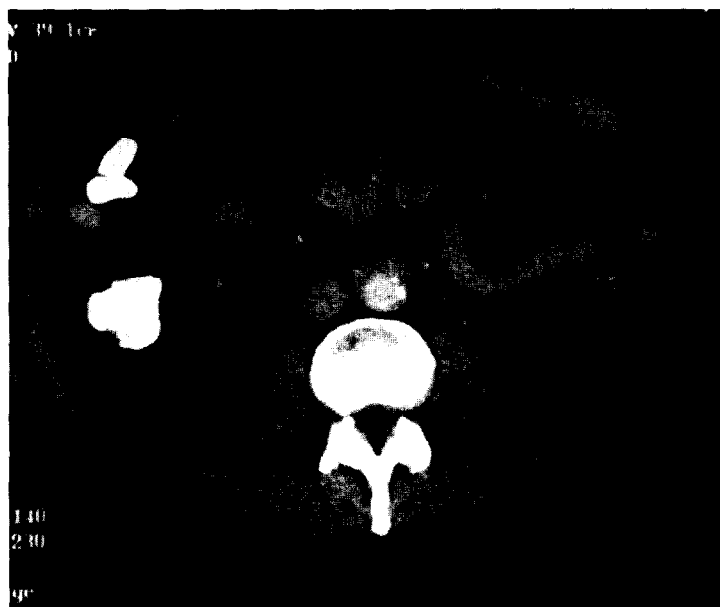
CT scan demonstrating an infiltrative mass in the root of the mesentery.
